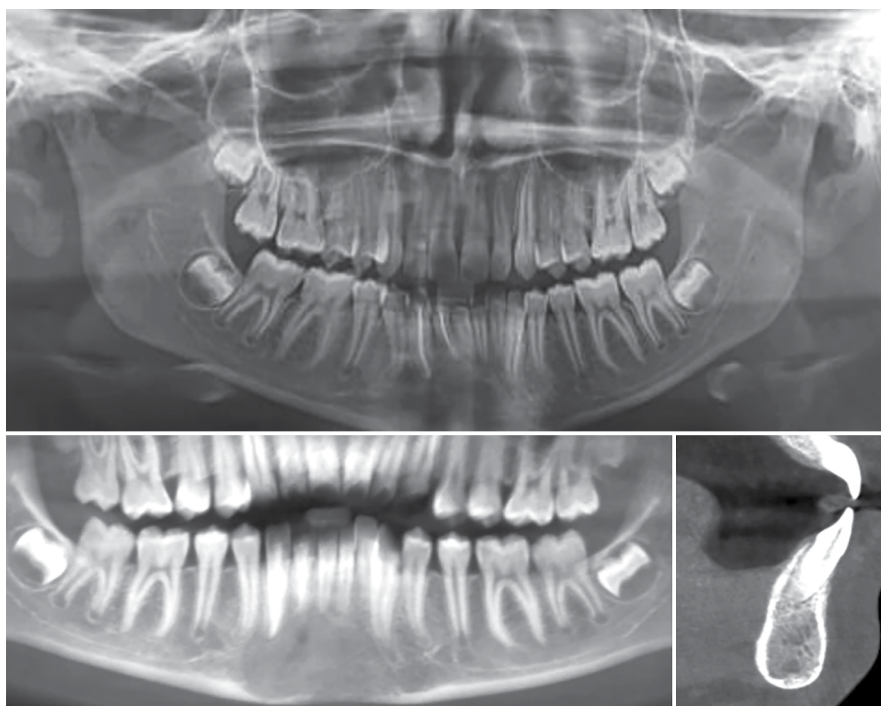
Orthopantomograph and CBCT at 6-month follow-up
